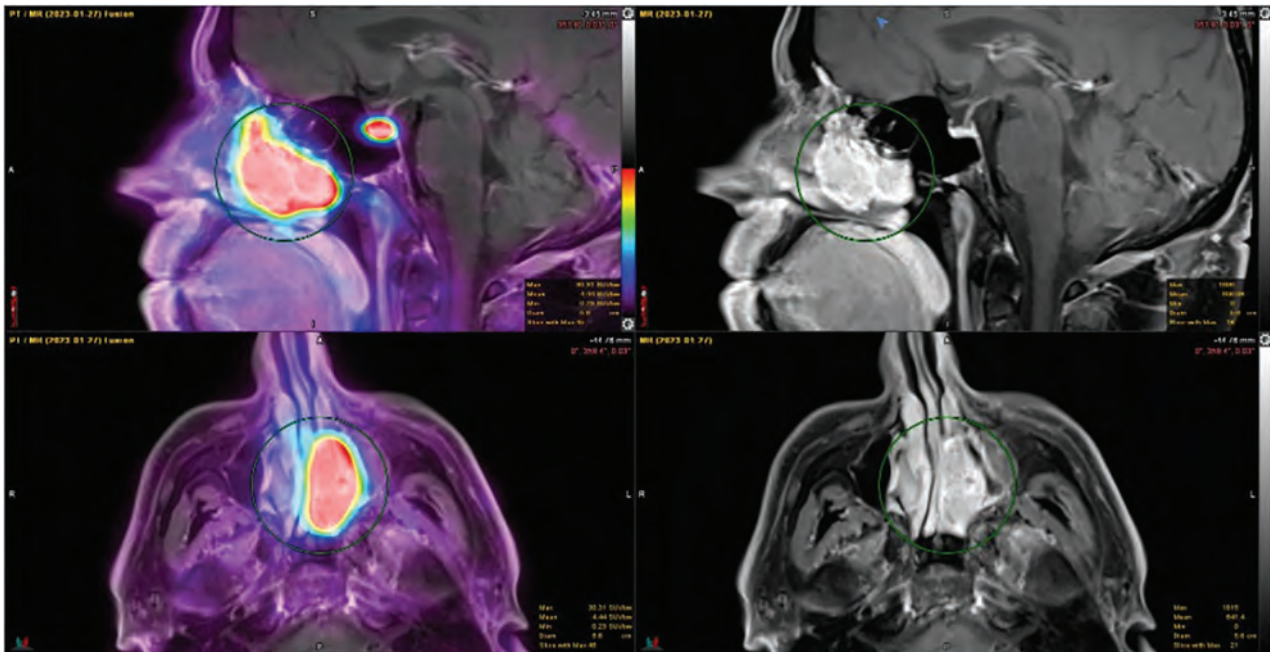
A 46-year-old man with a SSTR-avid homogeneously enhancing soft-tissue mass arising from the left nasal cavity, measuring $4.0 \times 1.9 \times 4.1$ cm in anterior-posterior by transverse by craniocaudal dimensions, consistent with biopsy-proved olfactory neuroblastoma (esthesioneuroblastoma). There was no evidence of intracranial tumor extension. In this example, SSTR-PET/MRI findings are comparable with the extent of disease identified by contrast-enhanced MR imaging.
